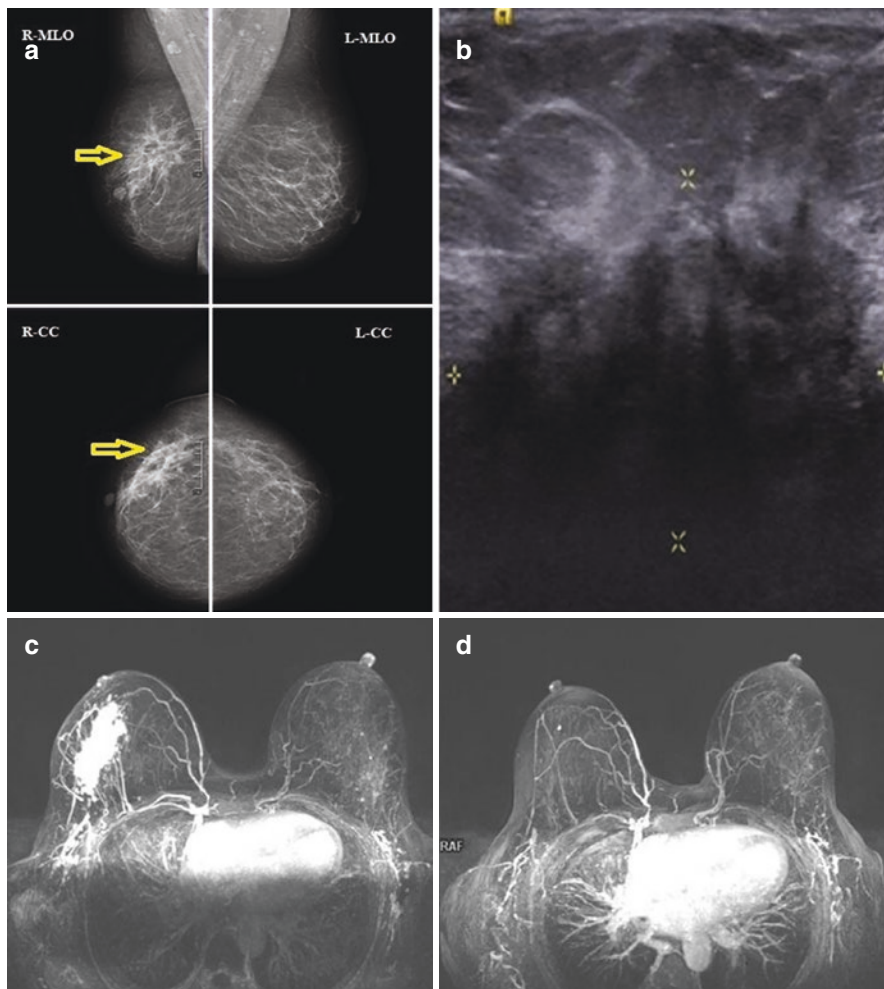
A 49 year old female presented with a right breast lump. Mammogram showed (a) large mass with distortion associated with spiculation (yellow arrows) in the upper outer quadrant of the right breast causing nipple retraction. Targeted breast ultrasound (b) revealed large abnormal area of shadowing associated with altered echo pattern, distortion and spiculations. MIP image (c) demonstrated large mass in the outer half of right breast. MIP image post 4 cycles of NACT (d) showed resolution of the abnormal area seen previously suggesting good response. HPE: grade 3 IDC
